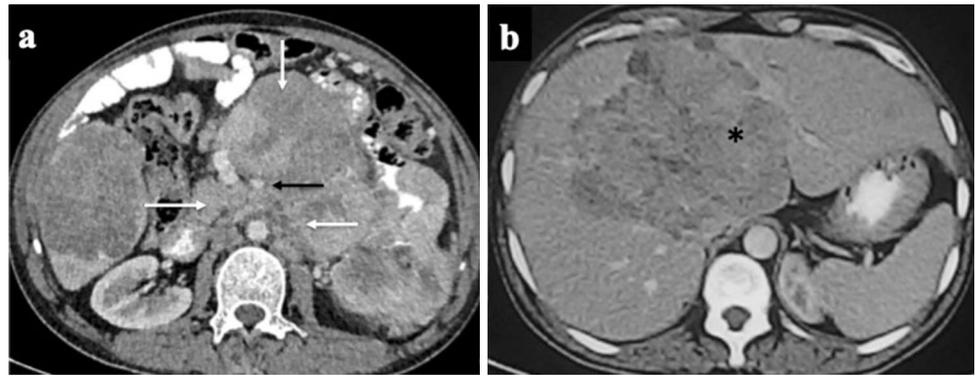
Mesenteric pseudotumor in a 41-year-old male presenting with gradually increasing lump in the abdomen for the last 25 years. Axial CT image showing a well-defined heterogeneously enhancing mass lesion (white arrows) in the mesentery and the mesenteric root showing multiple calcifications (black arrow)
